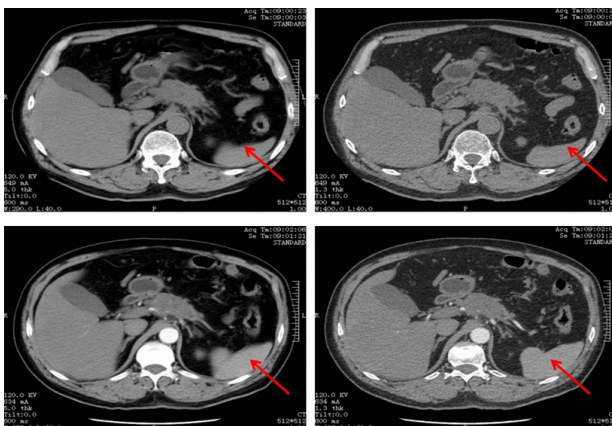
CT findings in a given patient. Male, 62 years old. Contrast-enhanced CT demonstrating a hypodense lesion (arrow) with peripheral enhancement in the pancreatic body.
